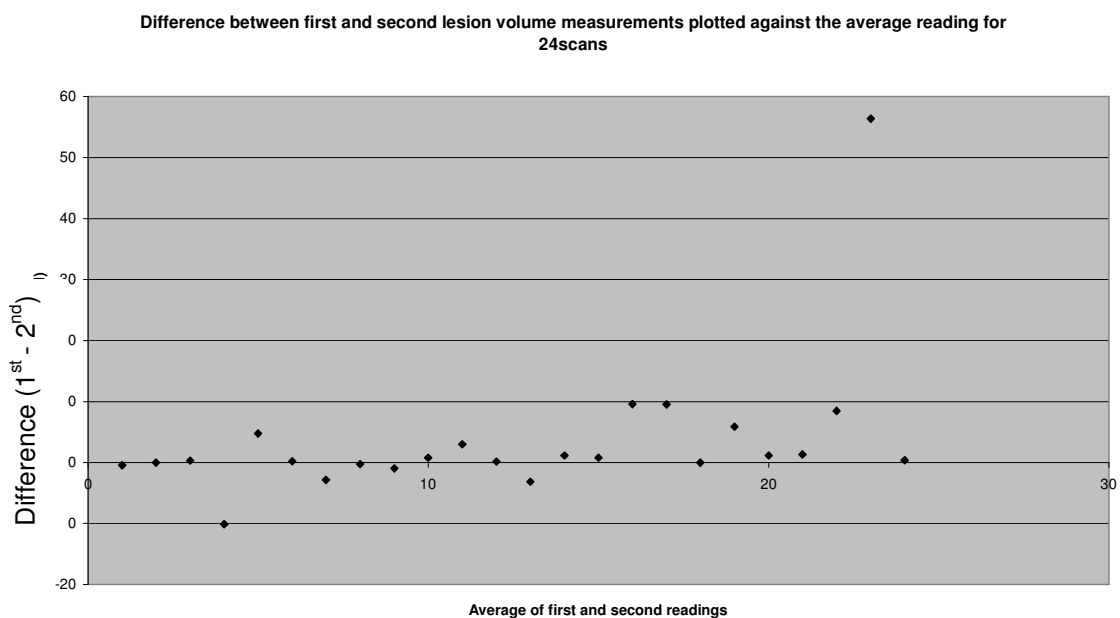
Difference between first and second lesion volume readings plotted against the average for the anonymised 24 duplicate scans (DWI and FLAIR)
